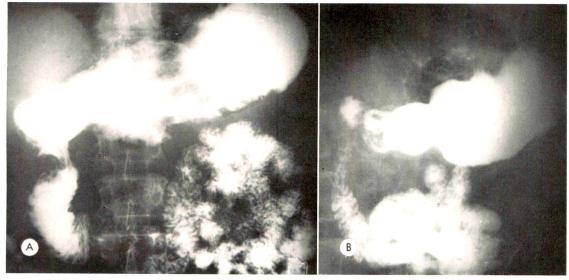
(A and B) Supine and right lateral roentgenograms. Carcinoma of head of the pancreas. A gastro-intestinal series performed on a patient with obstructive jaundice was entirely negative excepting for the supine and right lateral roentgenograms. A nodular defect is noted on the convex side of the descending duodenum, with an inverted 3 sign on the concave side. In the supine position, the pancreas indents the adjacent duodenum to elicit early pressure defects. In the lateral view, there is no enlargement of the retroduodenal space, but differential size in the space is present.
